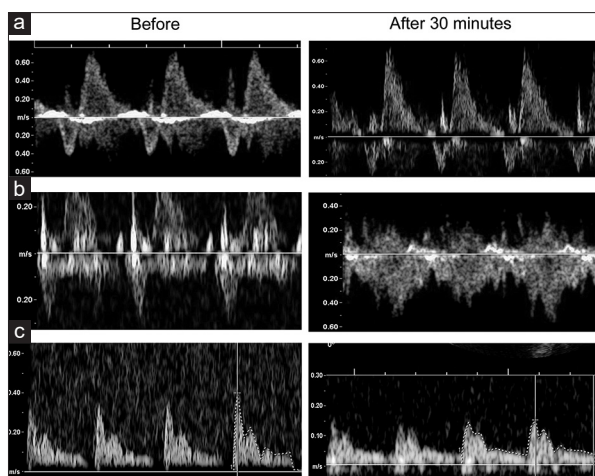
Fetal echocardiogram before and after maternal oxygen therapy for 30 min. (a) Increase in pulmonary artery forward (above baseline); Reverse (below baseline) velocity time integral ratio from 3.9 to 5.2. (b) Increase in pulmonary venous velocity time integral from 0.05 m to 0.14 m. (c) Acute decrease in middle cerebral artery pulsatility index from 3.1 to 1.7 attributed to ductus arteriosus constriction
